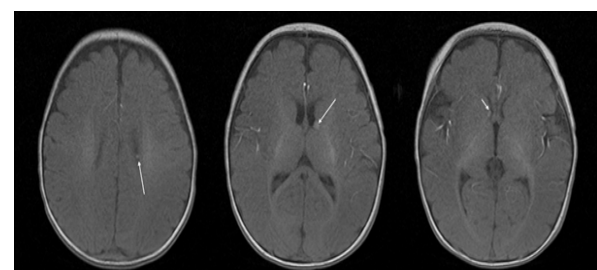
Brain MRI showing a few small, T1W high SI nodular lesions (arrows) suggesting subependymal hamartomas.
